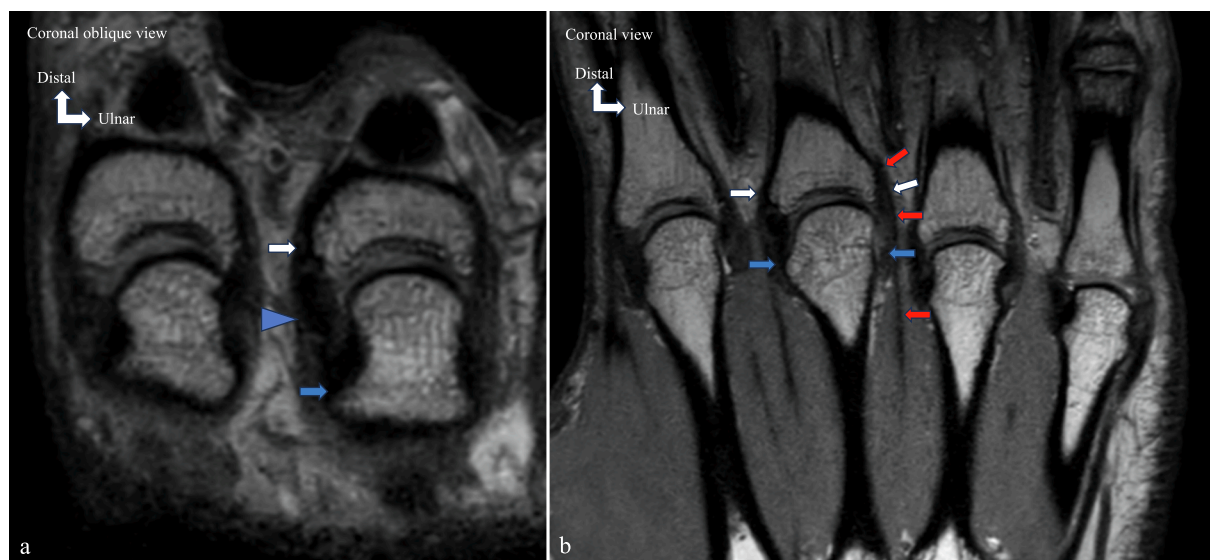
Collateral ligament and interosseous tendon. Proton density (PD) MRI in oblique dorsopalmar coronal reconstruction of the middle finger MCPJ (a) and coronal plane (b). Proximal attachments (blue arrows, a, b), distal attachments (white arrows, a, b), and body (arrowhead, a) of the proper collateral ligament. The interosseous tendon (red arrows, b) is clearly visualized.
